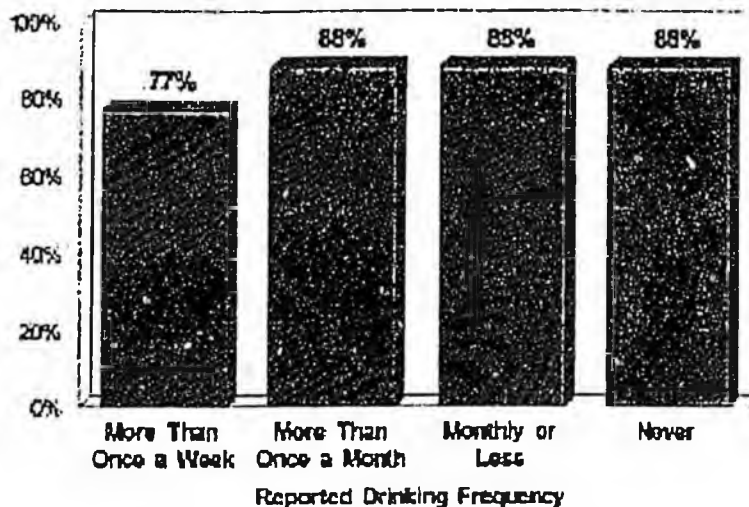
Perceived likelihood that DWI arrests will increase following new law by respondent drinking frequency.
